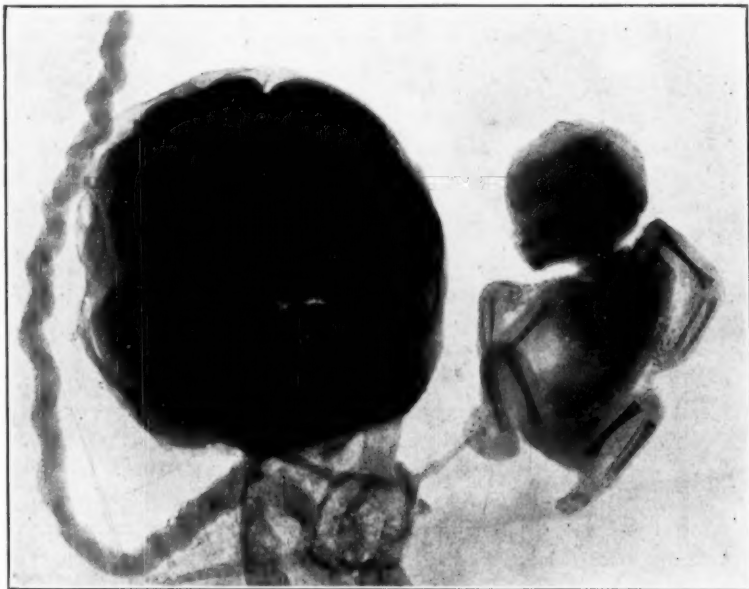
Photographic reproduction of x-ray of fetus papyraceous shortly after delivery showing the well-developed skeleton; also the comparative sizes of the two umbilical cords.
